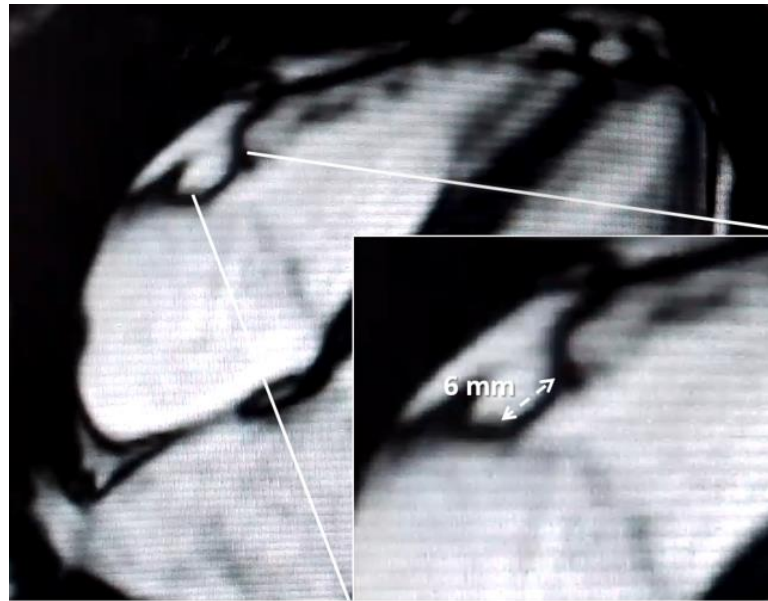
Cardiac magnetic resonance imaging, SSFP sequences. the examination confirmed the presence of mitral valve prolapse, showing the same features of those seen on transthoracic echocardiography including the absence of annular disjunction; furthermore, tricuspid valve prolapse was also confirmed, mostly involving the anterior leaflet; CMRi allowed to detect an associated significant tricuspid annular junction, with maximum separation between the right atrial wall/tricuspid valve and the free wall of the right ventricle of 6 mm, seen at the level of the portion of the ring adjacent to the anterior leaflet. Abbreviations: SSFP: steady state free precession, CMRi: cardiac magnetic resonance imaging.
